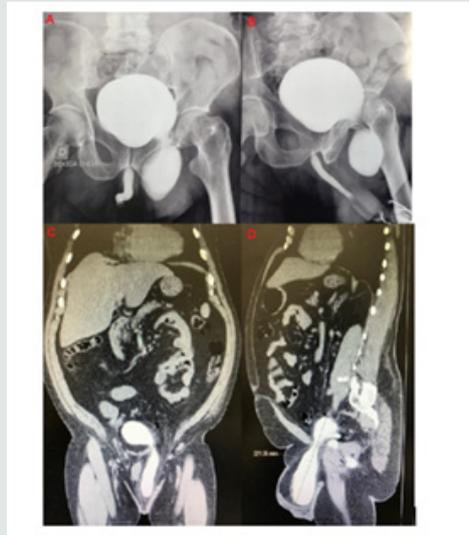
A and B- cystography indicating the prolapse of urinary bladder/ C- Abdominal CT showing the inguinal bladder hernia -coronal view and D- sagittal view.
